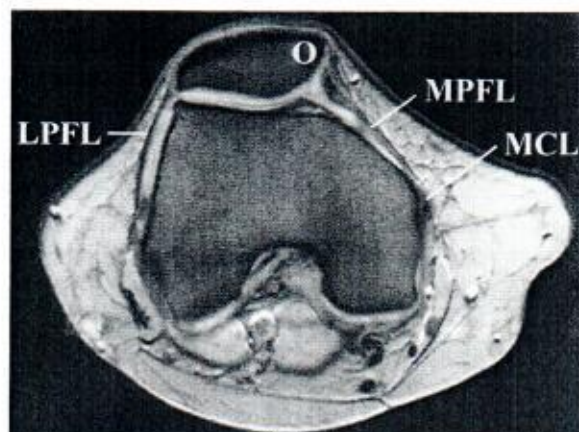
Normal MR anatomy of the patellar retinaculum on a T1-weighted Flash 2D sequence. The superior portion of the medial patellofemoral ligament (MPFL) has a broad fibrocartilaginous attachment to the odd facet (O) of the patella and is dorsally attached to the femoral condyle and medial collateral ligament (MCL) with extension to the fascia of the dorsal muscles. LPFL, Lateral patellofemoral ligament
